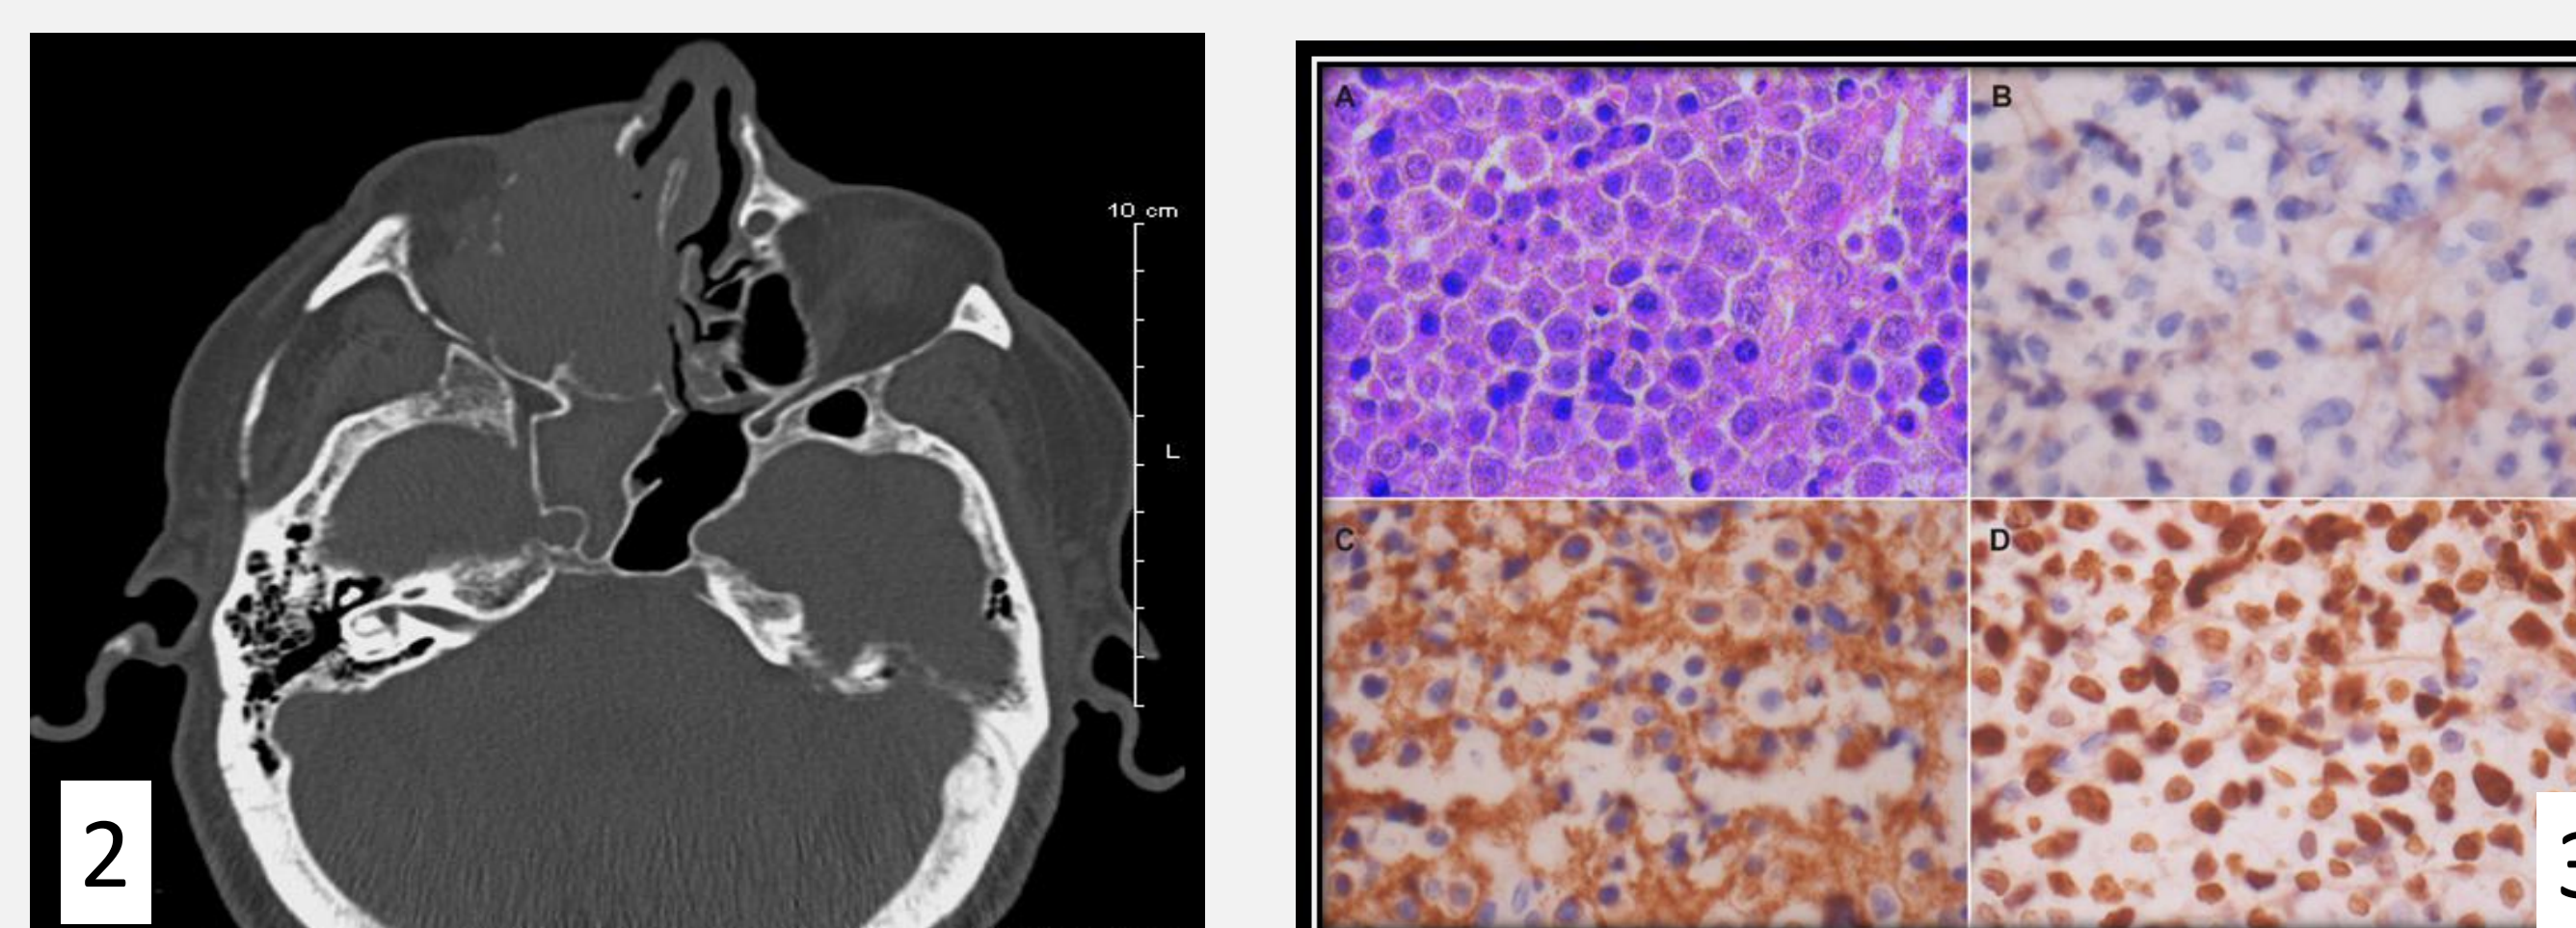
CT scan of sinuses shows mass extending into the right maxillary and ethmoidal sinuses with multiple areas of bony erosion. The mass also extends through the cribriform plate into the anterior cranial fossa and the right orbit causing right globe proptosis (axial view)
